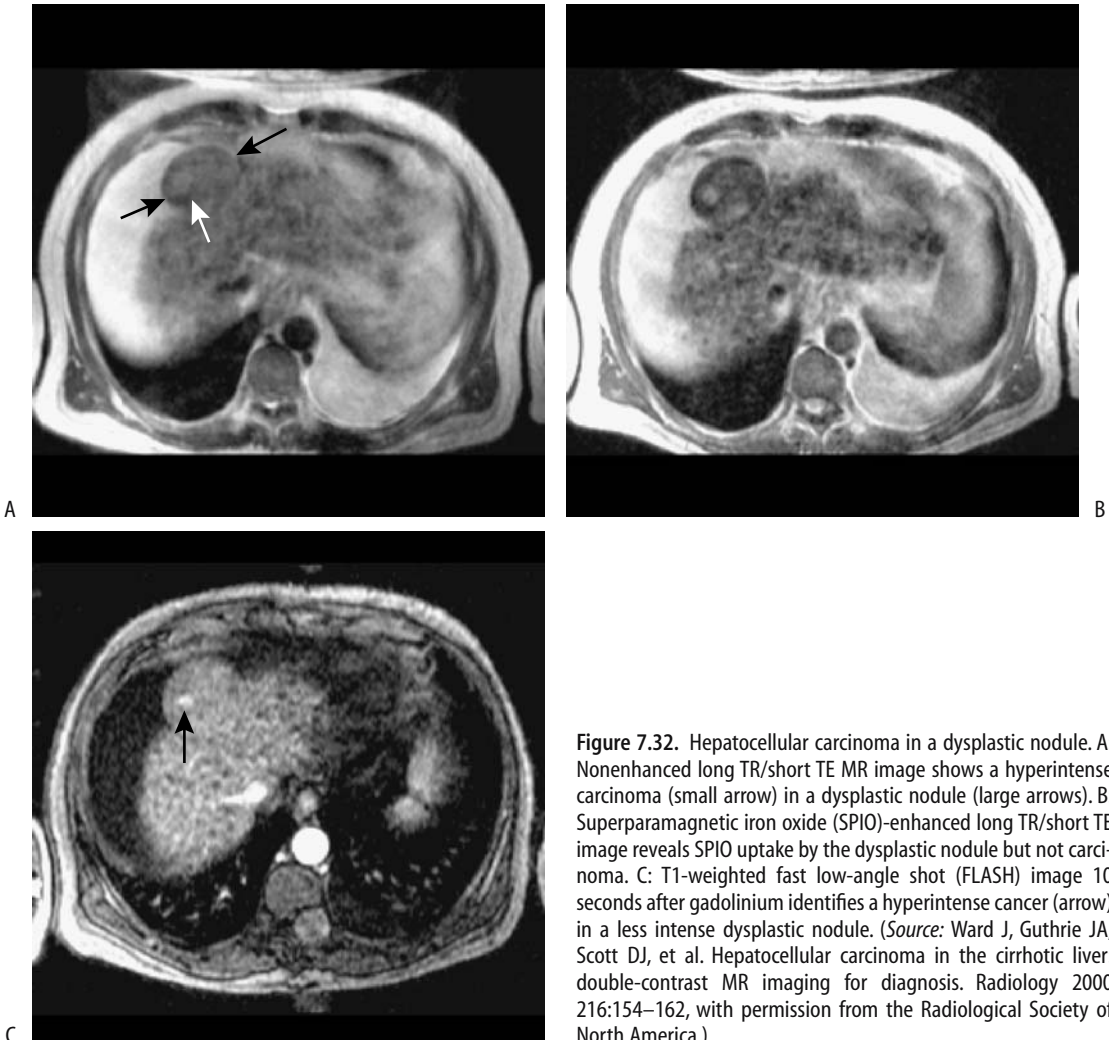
Hepatocellular carcinoma in a dysplastic nodule. A: Nonenhanced long TR/short TE MR image shows a hyperintense carcinoma (small arrow) in a dysplastic nodule (large arrows). B: Superparamagnetic iron oxide (SPIO)-enhanced long TR/short TE image reveals SPIO uptake by the dysplastic nodule but not carcinoma. C: T1-weighted fast low-angle shot (FLASH) image 10 seconds after gadolinium identifies a hyperintense cancer (arrow) in a less intense dysplastic nodule. (Source: Ward J, Guthrie JA, Scott DJ, et al. Hepatocellular carcinoma in the cirrhotic liver: double-contrast MR imaging for diagnosis. *Radiology* 2000 216:154–162, with permission from the Radiological Society of North America.)
